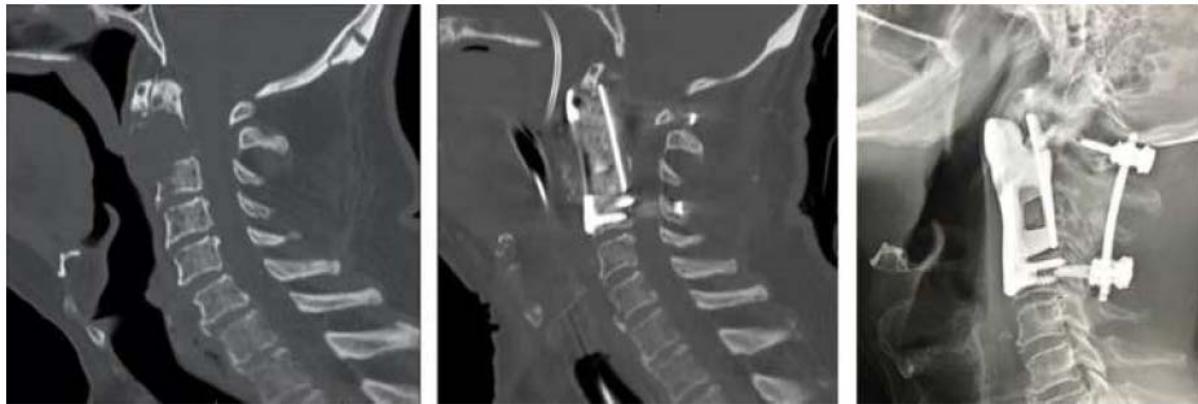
Left: Pre operative CT, sagittal, showing almost complete erosion of the body of C2. Middle: intraoperative CT showing graft-filled implanted device. Right Post-operative lateral X-ray showing stable device positioning.
